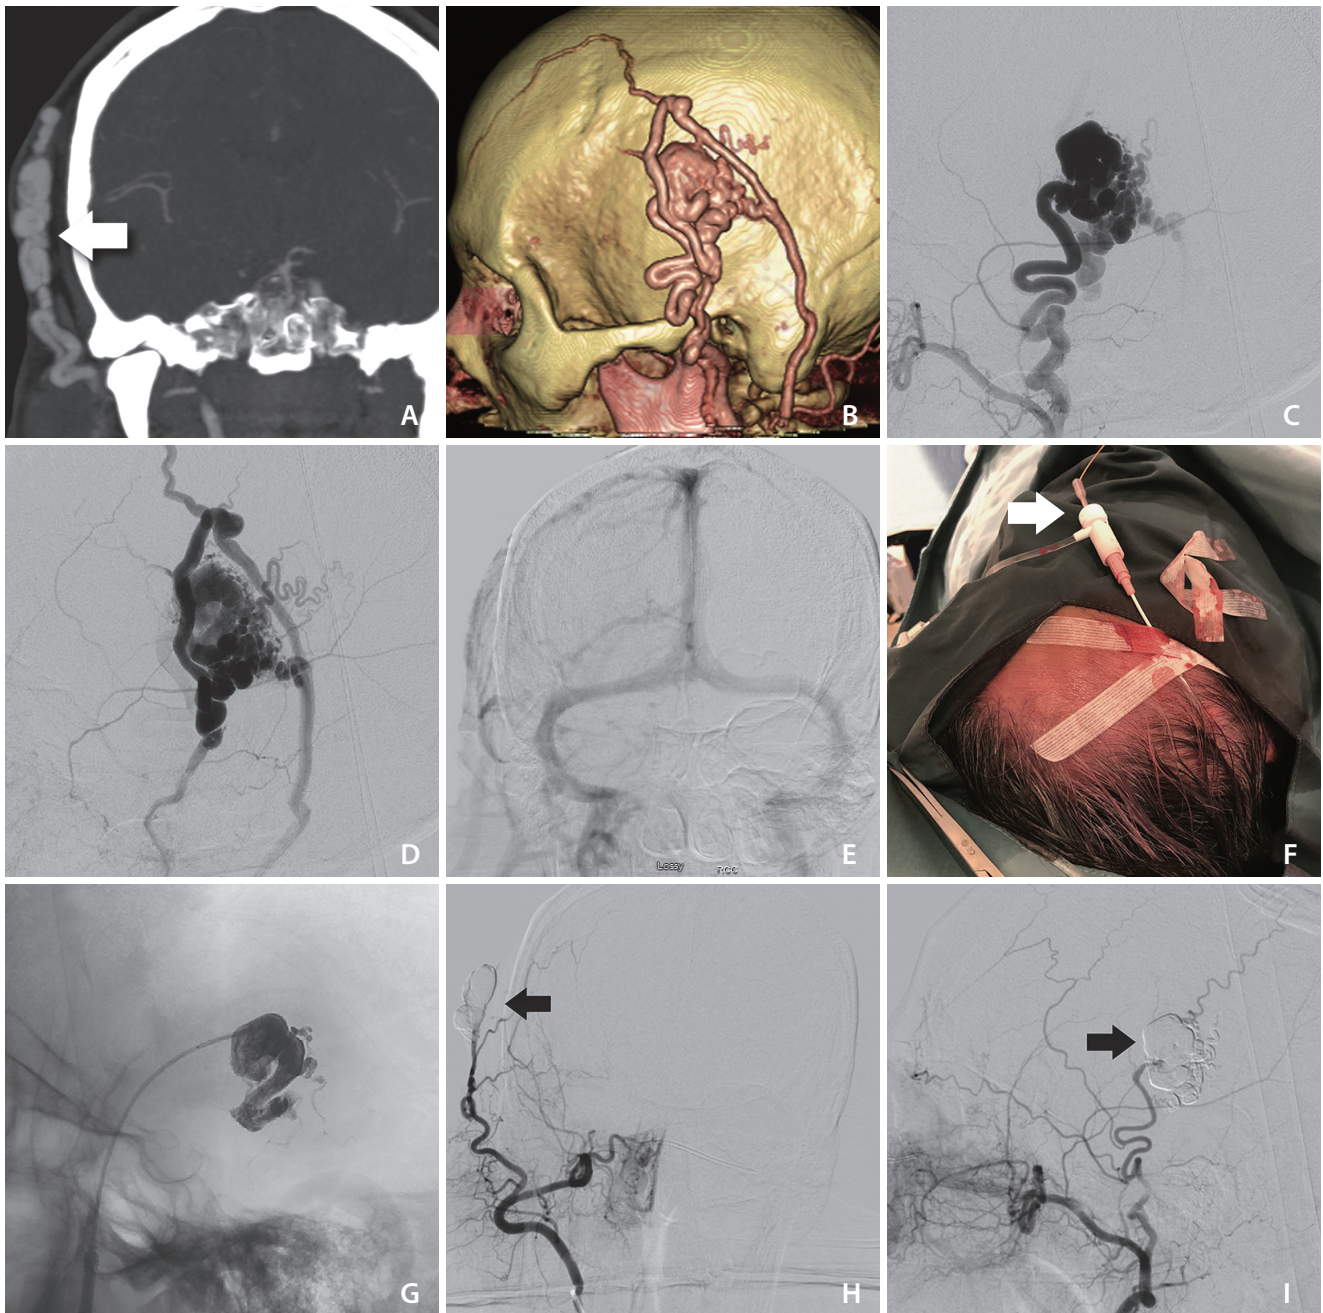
Brain CTA in coronal view (A) shows enlarged vessels in the right scalp area (arrow), fed by the right superficial temporal artery as seen on 3D reconstruction (B). The angiogram (C, D) confirms the presence of an enlarged superficial temporal artery feeding an arteriovenous fistula with a large venous pouch and several enlarged veins, with eventual drainage into the superior sagittal sinus (E). (F) The Apollo catheter is inserted into the check flow valve using the tip of the Terumo wire housing as an introducer (arrow). The valve is attached to the Angiocath cannula from the thin wall entry needle, and together these act as a sheath directly placed inside the scalp lesion. Using this setup, we were able to inject liquid embolic agent directly into the nidus with no arterial reflux thanks to manual external compression of the feeding superficial temporal artery. (G) The patient's symptoms fully resolved immediately after the procedure. (H, I) The 6-month follow-up angiogram confirmed the complete obliteration of the lesion (arrow).
